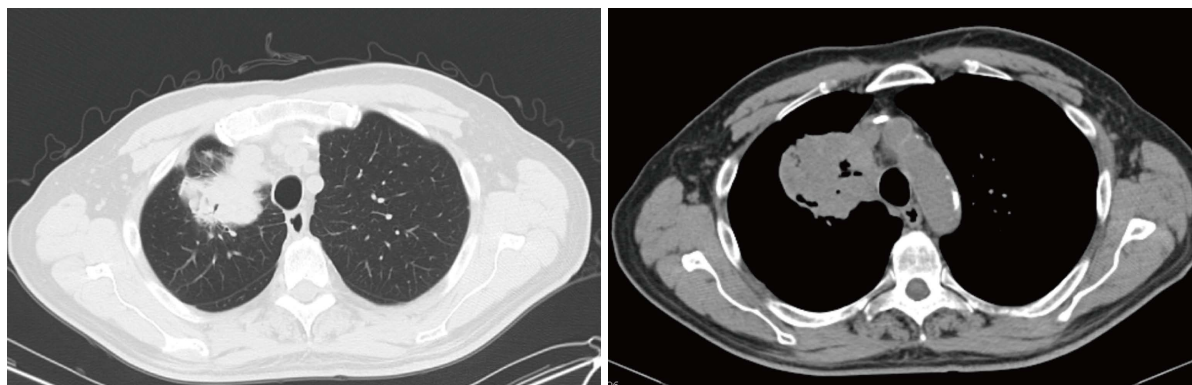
Chest computed tomography-scan demonstrating 7.9 × 7.8 cm mass in the right upper lobe and right sided mediastinal and hilar lymphadenopathy.
